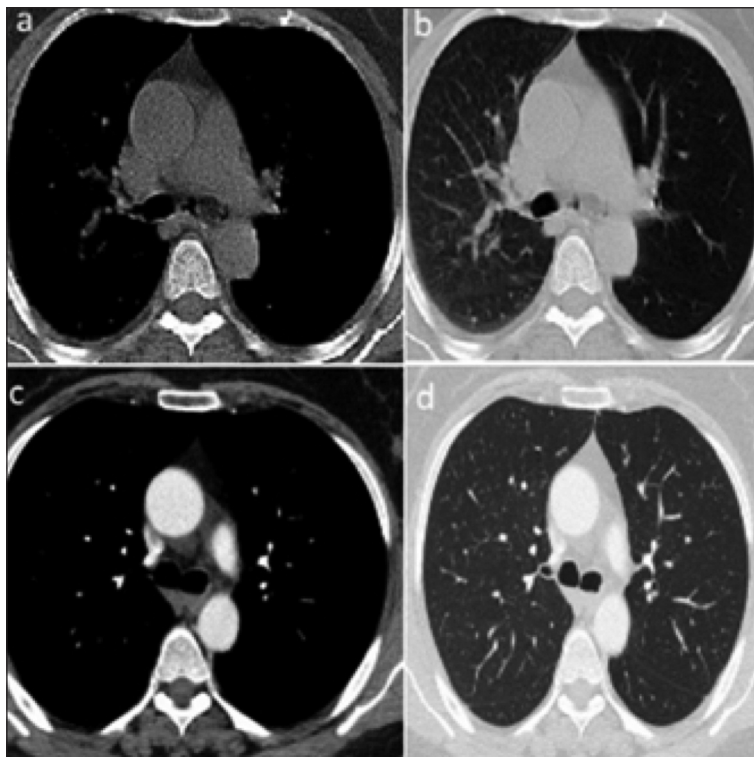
Thorax computed tomography scan showing a, b) the presence of a solid endobronchial lesion subtotally occluding the main left bronchus, c, d) totally opened left main bronchus after endobronchial treatment.
